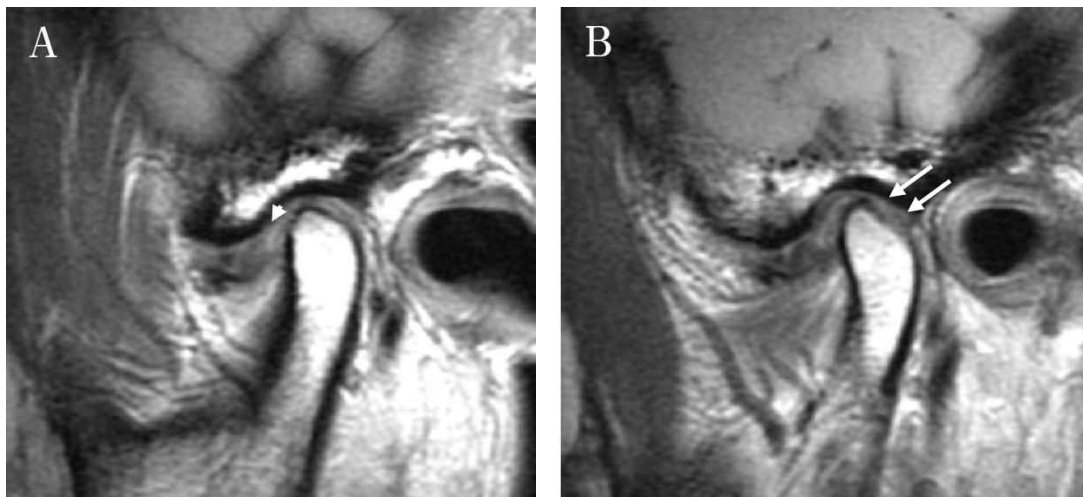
Post-treatment proton density weighted magnetic resonance images of right TMJ in closed jaw position. A: midsagittal cross-sectional view of condyle. White arrowhead indicates the distal end of displaced disc. B: slightly medially cross-sectional view of condyle. Two white arrows indicate the flattening in posterior portion of condyle and the relief of collapse of posterior articular space
